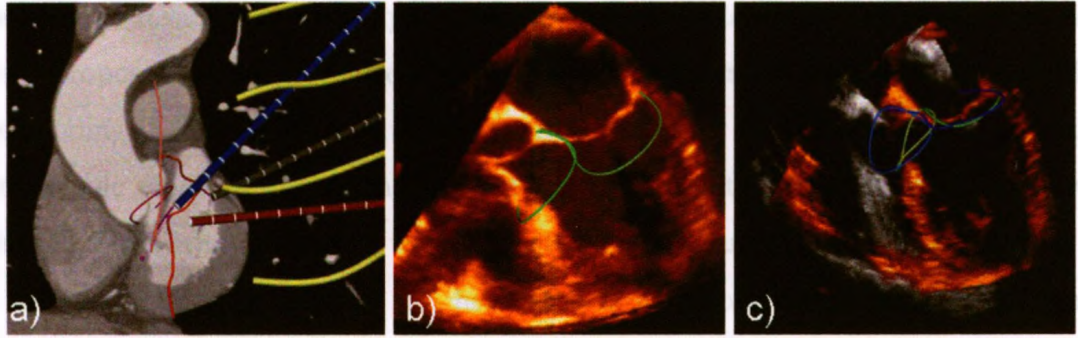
(a) Pre-operative surgical planning based on pre-operative CT image, showing left anterior descending artery (red), robotic arms and intercostals space (yellow lines); (b) US images of left lung deflation stage with the aortic valve and mitral valve extracted; (c) The shift from left lung deflation (orange) to the thoracic insufflation (gray) and their corresponding segmented valvular structures.
